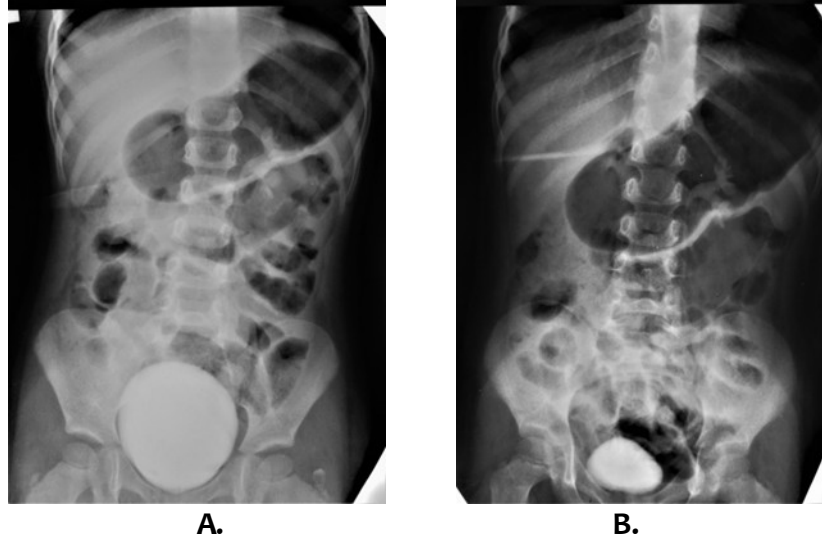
X-ray examination - vascular cystography of a 3-year-old child with VUR III on the left
